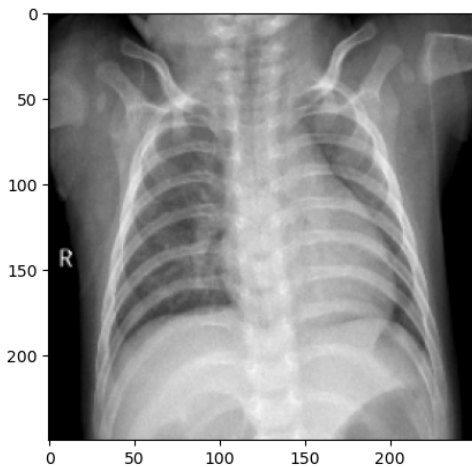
Example of chest X-ray patient without Covid-19
